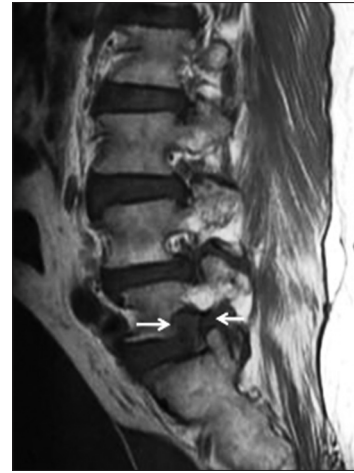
Case of Grade 2 neural foraminal stenosis, Lee system. T1-weighted sagittal image of a 65-year-old woman shows vertical and transverse stenosis of the left L5-S1 neural foramen (arrow) due to annular bulge. Note the circumferential obliteration of the perineural fat. This neural foramen also qualifies for Wildermuth Grade 3 neural foraminal stenosis
